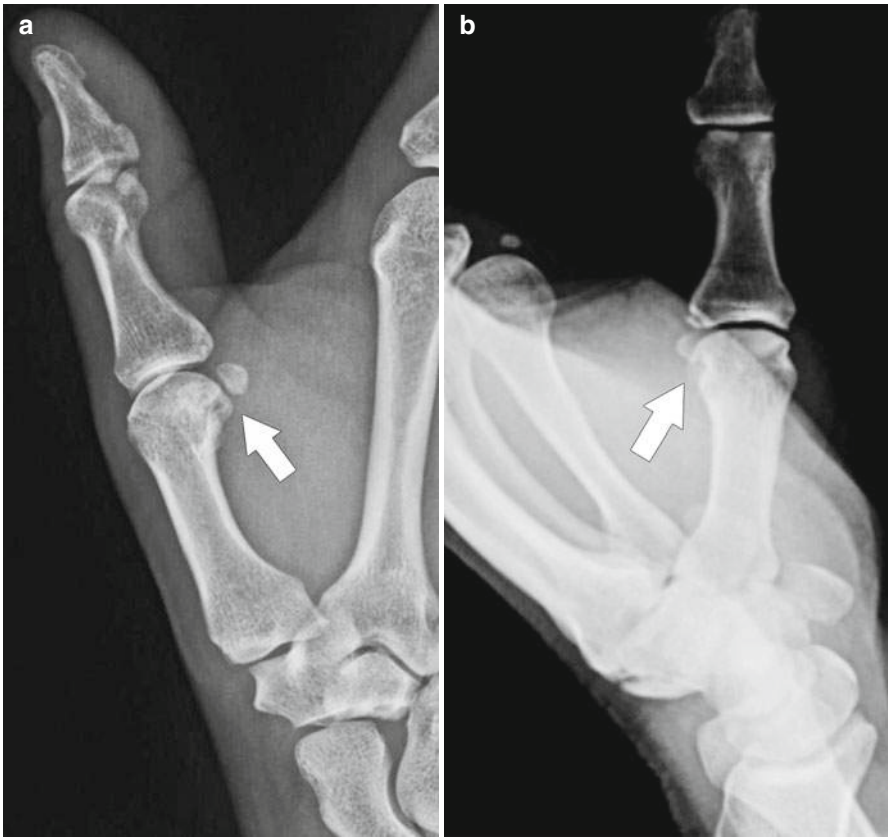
Gamekeeper's thumb fracture. Thumb X-ray posteroanterior (a) and lateral (b) views reveal bony avulsion of the ulnar aspect of the base of the 1st metacarpal
